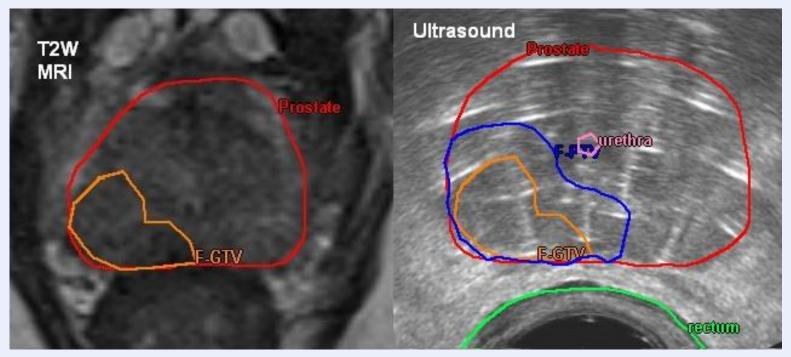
Image registration MRI-TRUS
